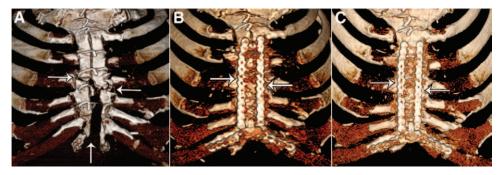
Three-dimensional computed tomography image. Fracture sites and regions of sternal nonunion are indicated by arrows preoperatively (A), and healed fractures are indicated by arrows at 3 months (B) and 9 months postoperatively (C).
